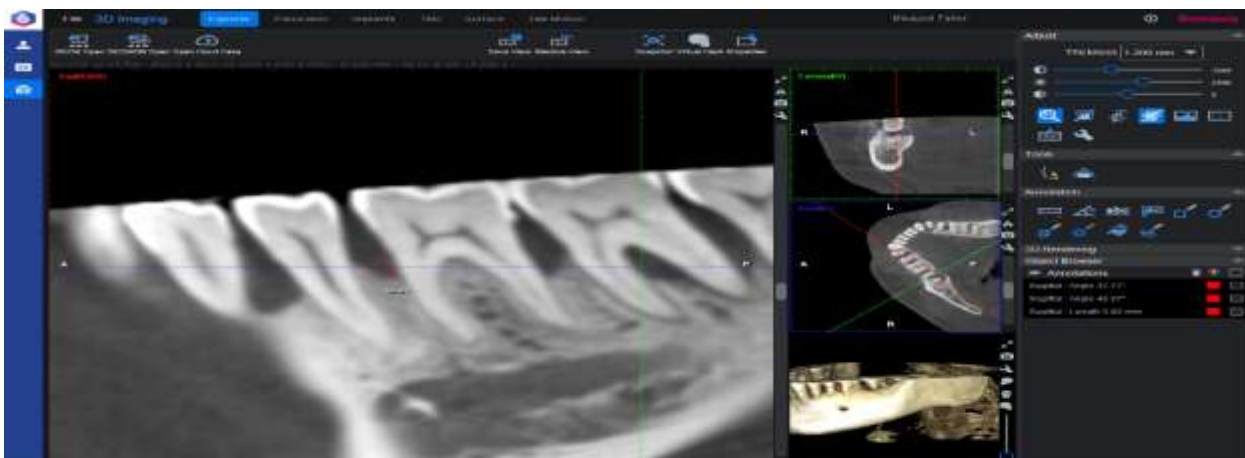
CBCT sagittal cut showing defect angulation measurements of an intrabony defect at mesial aspect of upper right first premolar before therapy: defect width, angle between root surface and lateral bony wall.
